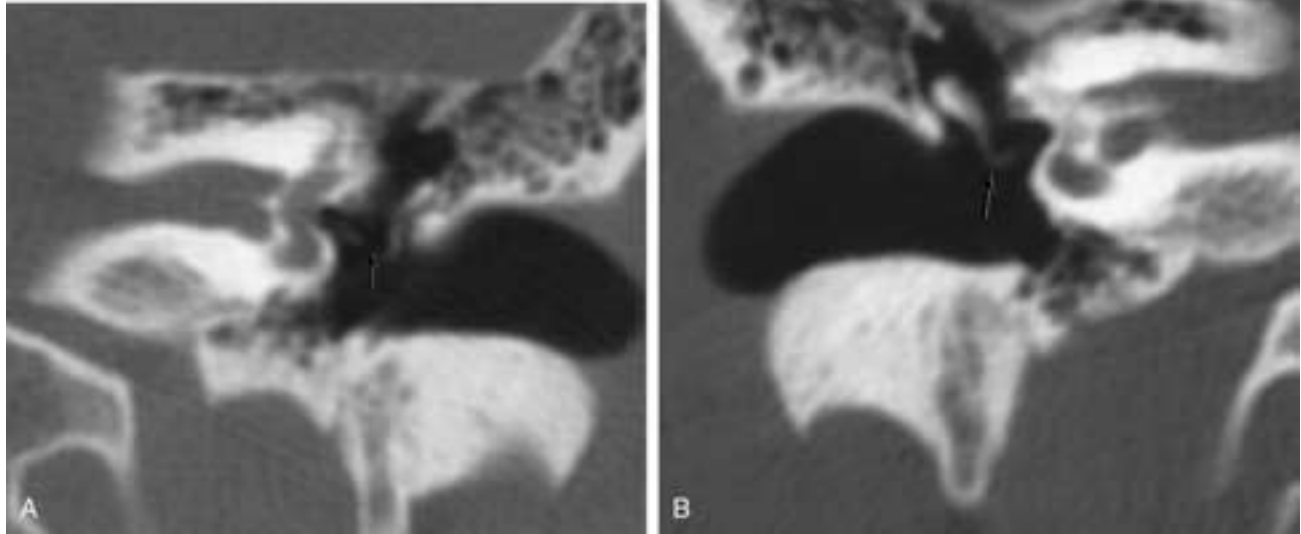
Incudostapedial subluxation. A, Coronal CT image, left ear. Note the separation between the distal incus and the stapes on this coronal image (*arrow*). Diagnosis in this plane is ordinarily quite difficult. B, Coronal CT image, right ear. Normal side for comparison. Note the relationship of incus to stapes (*arrow*).
